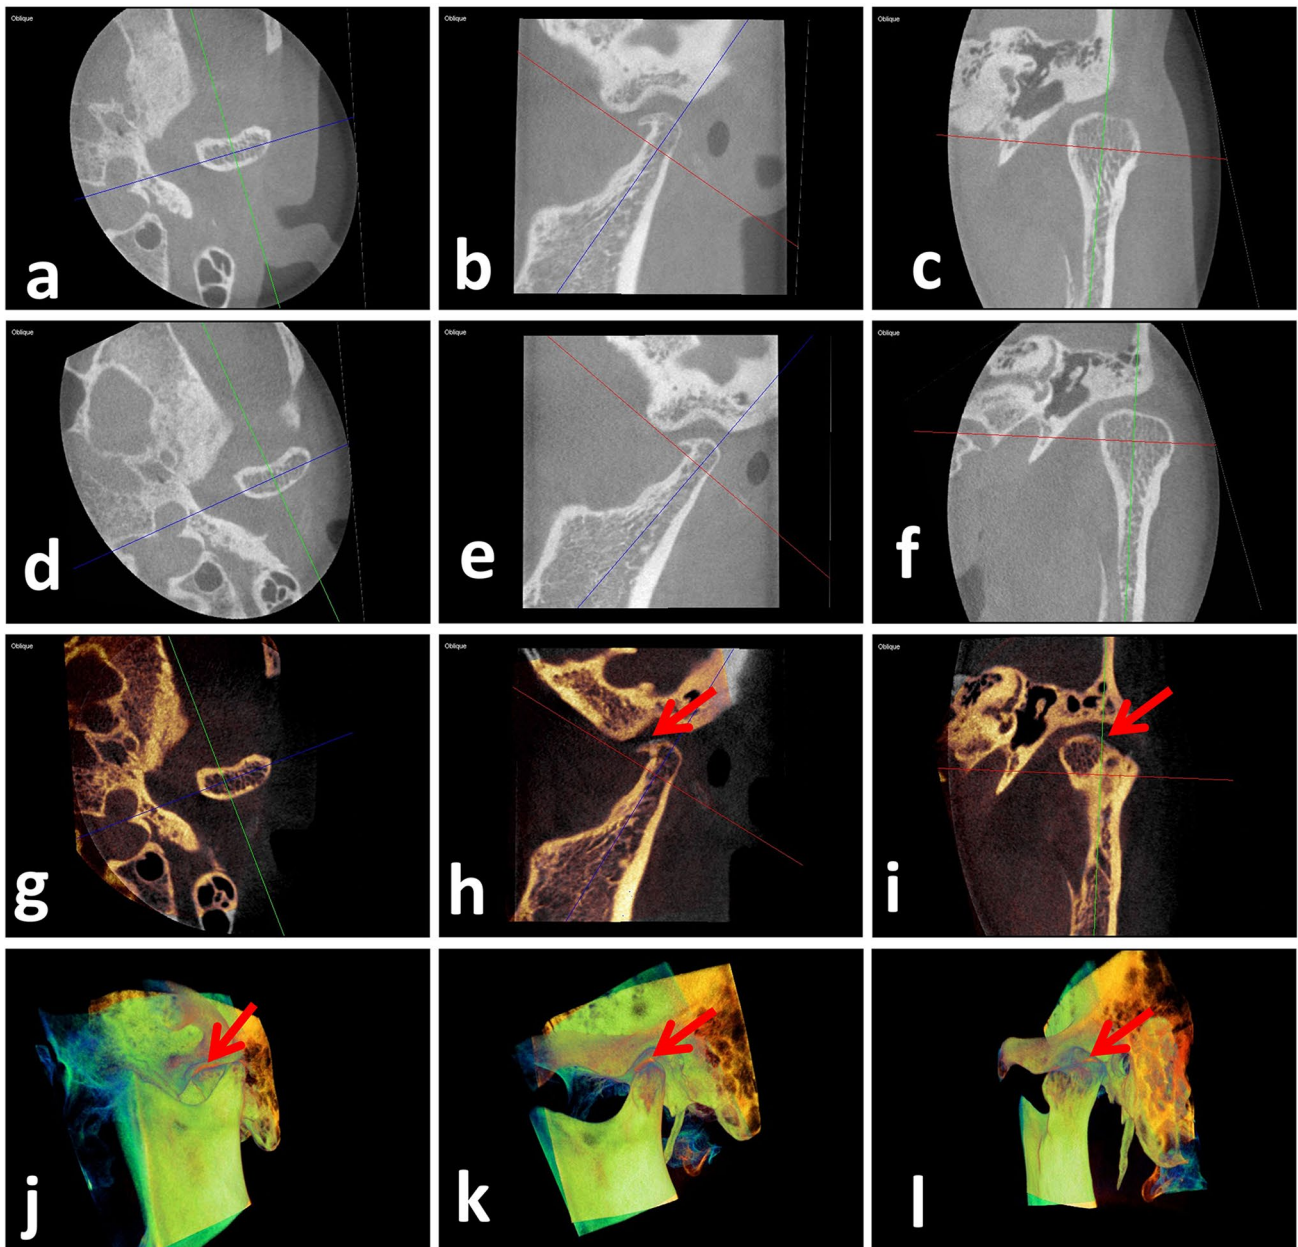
Example images for the condyle with tiny bone resorption. Axial (a), oblique coronal (b), and oblique sagittal (c) view of the T1 CBCT images; axial (d), oblique coronal (e), and oblique sagittal (f) view of the T2 CBCT images; axial (g), oblique coronal (h), and oblique sagittal (i) view of the fused sectional CBCT images. The
